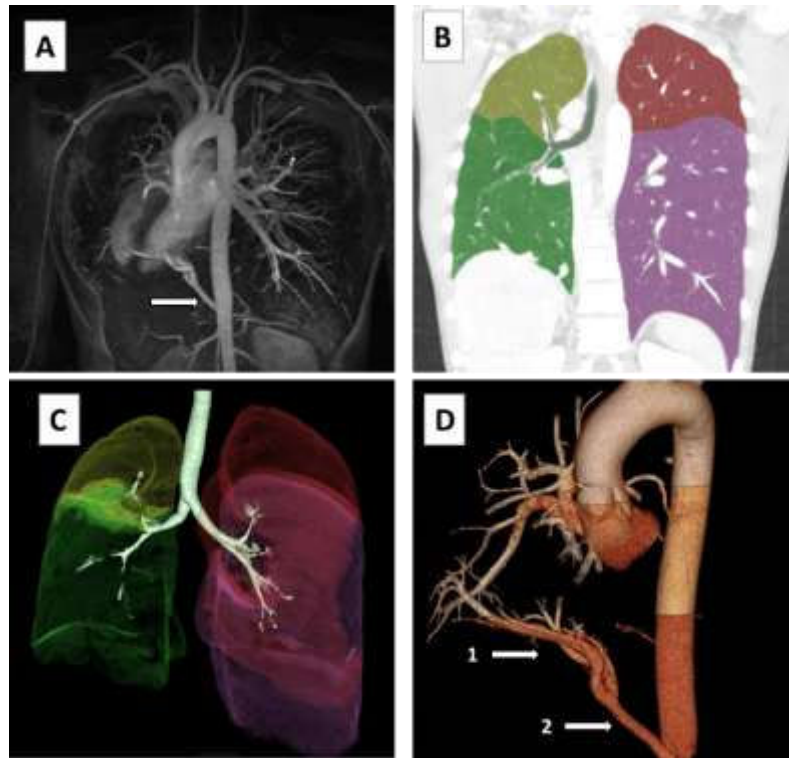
Multimodal Imaging Findings. A) Cardiac MRI showing dextrocardia and an anomalous systemic arterial supply to the right lower lobe (arrow). B) Coronal computed tomography image of the chest with automated pulmonary lobe segmentation, highlighting the agenesis of the right upper lobe, with the right middle and lower lobes displayed in yellow and green, respectively. The left upper and lower lobes are fully visualized and color-coded in red and purple. C) 3D reconstruction of the tracheobronchial tree revealing the absence of the right upper lobe bronchus. Both B and C were obtained using Synapse 3D® (Fujifilm). D) 3D vascular reconstruction from the thoracic CT scan detailing the anomalous systemic arterial supply to the right lower lobe (1), originating from the hepatic artery (2)
